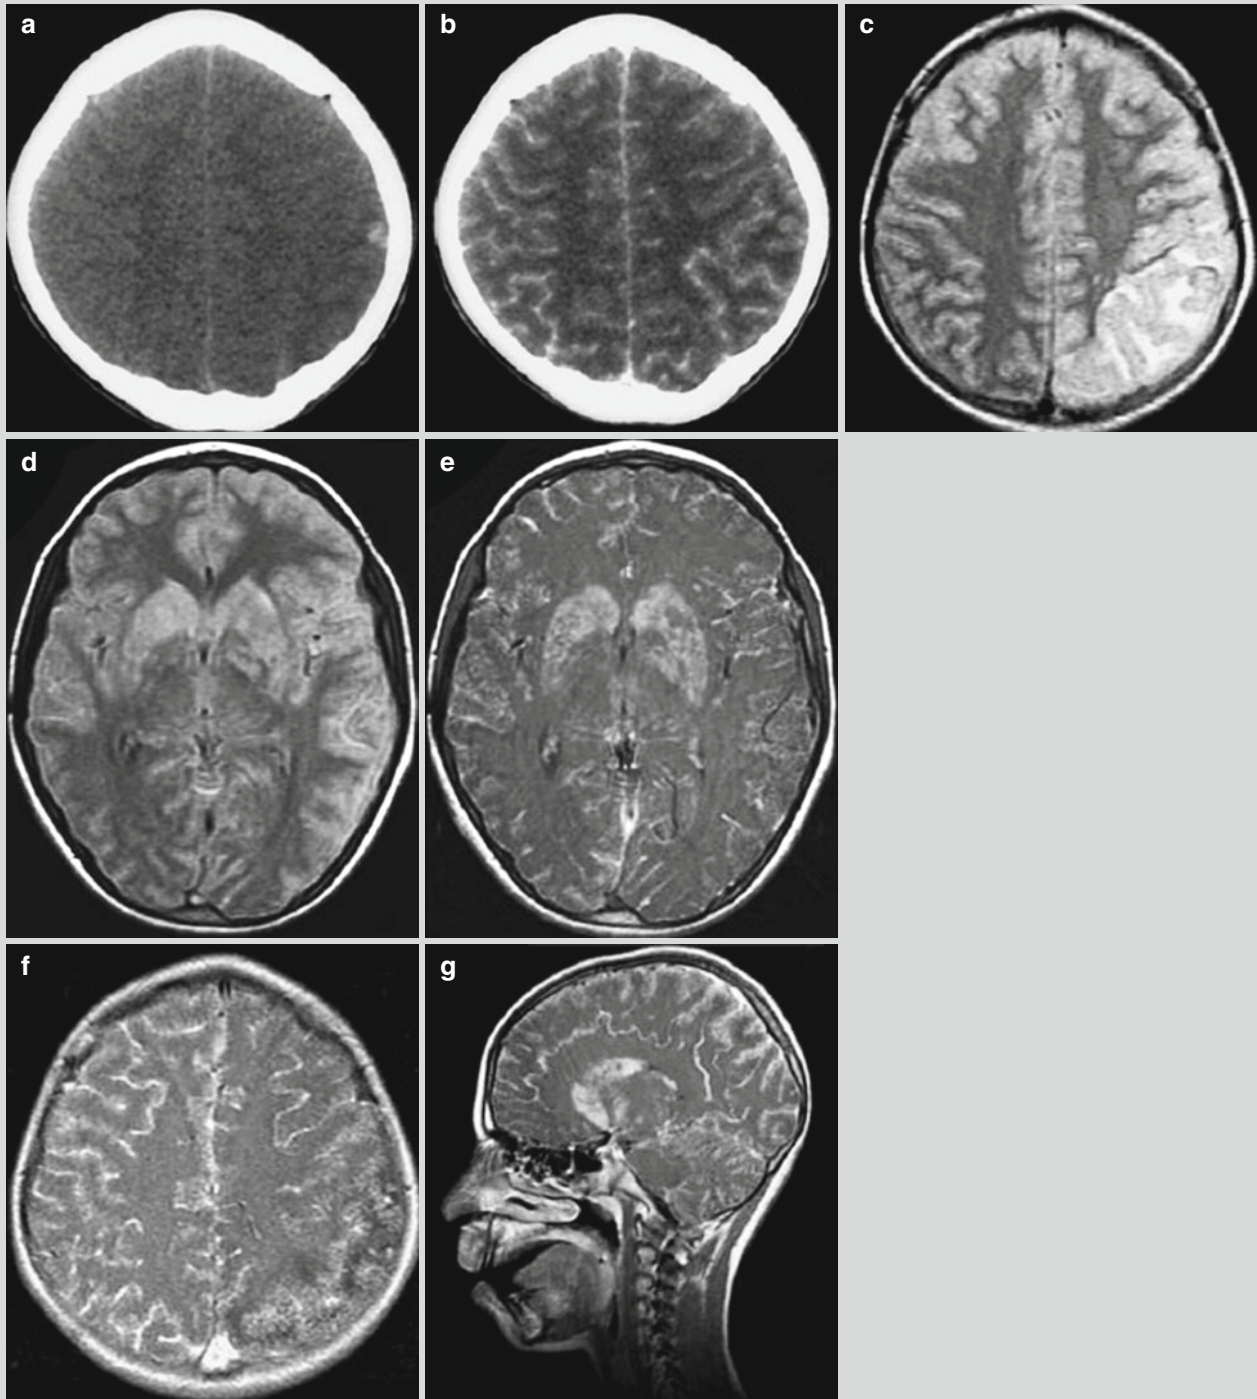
Anthrax meningitis. (a, b) Plain CT scanning demonstrates hemorrhagic left parietal lobe and diffuse enhancement of meninges. (c, d) FLAIR imaging demonstrates high signal from the parietal lobe and basal ganglia. (e–g) Enhanced MR imaging
